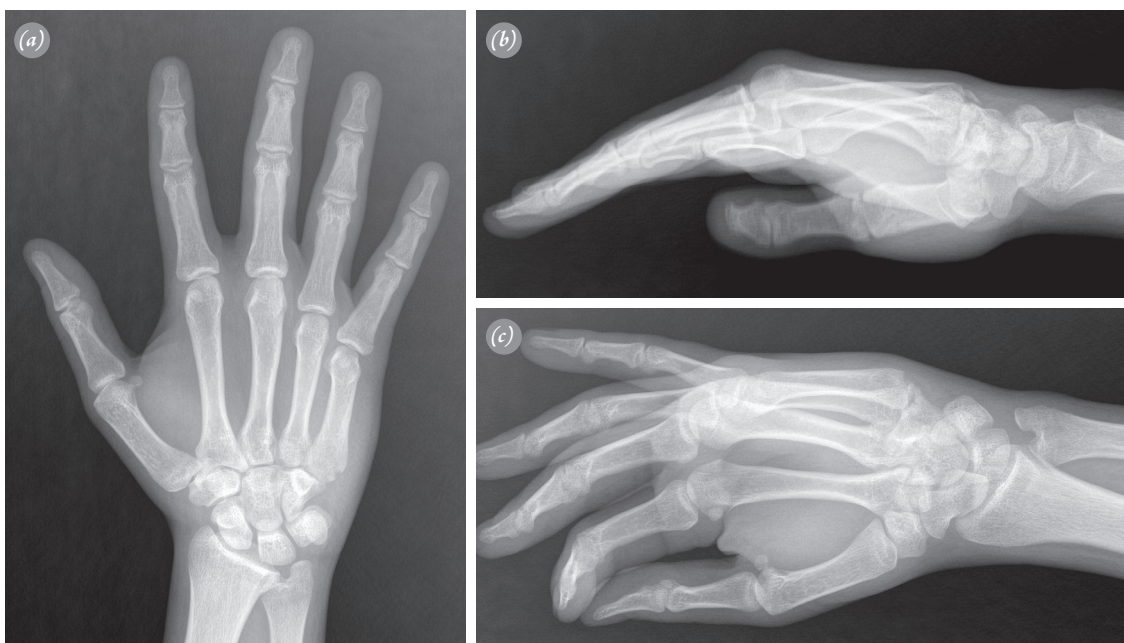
(a) Anteroposterior, (b) lateral, and (c) 45° oblique view radiographs of a 20-year-old male injured after punching a wall.
